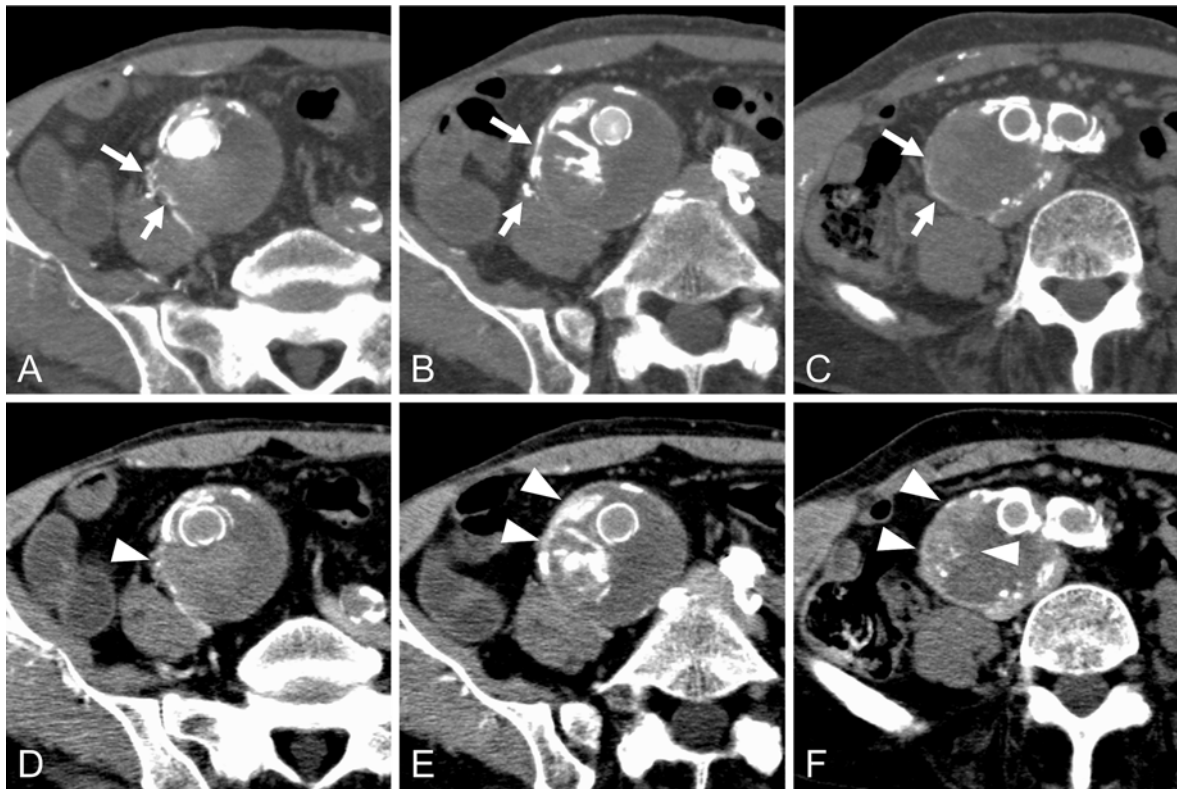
Plain CT (A) and contrast-enhanced CT (B) before embolization. Contrast enhanced CT shows an endoleak of unknown origin (arrows) and aneurysmal wall enhancement (arrowheads).
